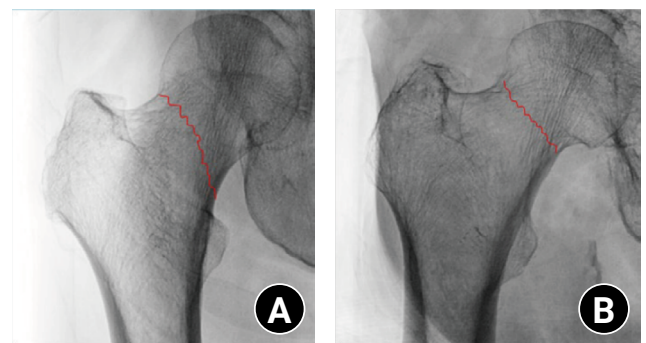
Relationship between the Pauwels angle and bone mineral density (BMD). (A) Radiograph of a female patient with relatively high BMD (T-score, -1.5). The preserved primary compression trabeculae (PCTs) are associated with a vertically oriented fracture line, resulting in a steeper Pauwels angle. (B) Radiograph of a female patient with low BMD due to advanced osteoporosis (T-score, -4.5). Loss of PCTs leads to a more horizontally oriented fracture line and a decreased Pauwels angle.
